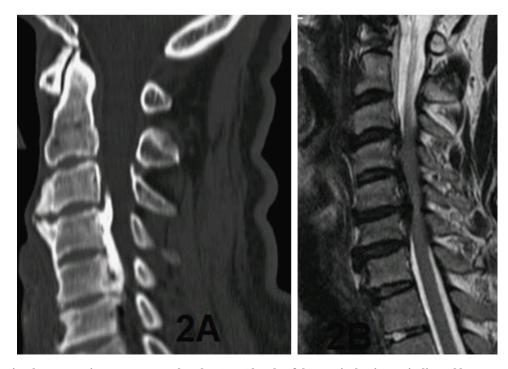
The maximal compression area occurred at the C5–C6 levels of the cervical spine as indicated by preoperative sagittal CT (A) and sagittal T2-weighted MRI images (B).
